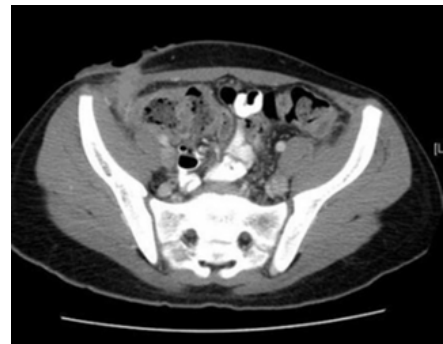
CT scan 6 weeks later showing complete closure of the fistula.
